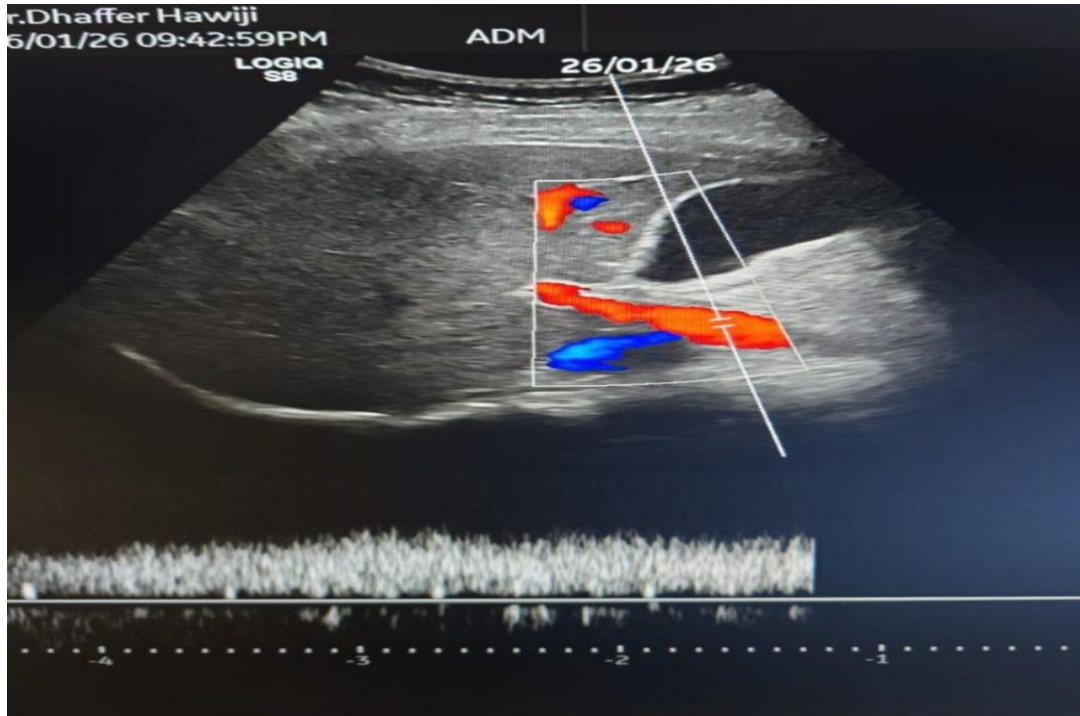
Color Doppler ultrasonography revealing increased gallbladder wall vascularity, suggestive of inflammatory hyperemia.
